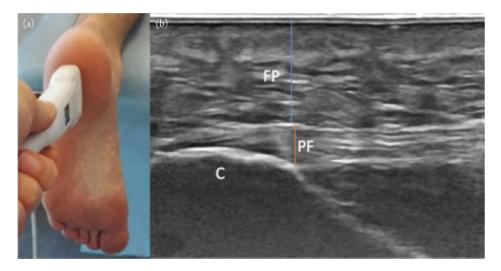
Ultrasound of normal plantar fascia. The transducer is placed in a longitudinal plane from heel to toes (Panel (a)). On ultrasound (Panel (b)), the calcaneus (C) is identified, along with the superficial fat pad (FP) and the plantar fasia (PF). Notice that the plantar fascia is normally ≤4 mm and hyperechoic in relation to the fat pad. From Figure 1 of Hansen L, Krogh TP, Ellingsen T, Bolvig L, Fredberg U. Long-term prognosis of plantar fasciitis: a 5- to 15-year follow-up study of 174 patients with ultrasound examination. Orthop J Sports Med. 2018;6(3):2325967118757983.
